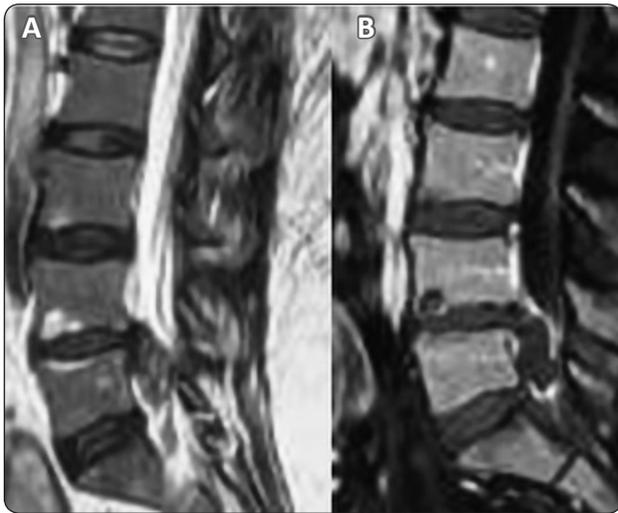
Sagittal MR images (T2-weighted image (left) and T1-weighted image (right)) for a patient with L4-5 disc herniation associated with type I MC. The patient underwent simple discectomy without fusion with removal of the caudally migrated disc fragment.
